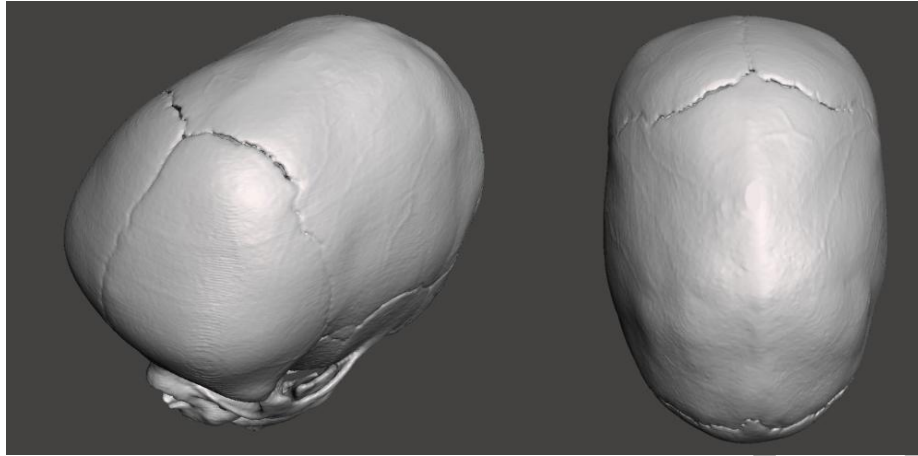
Head CT of a 4-month-old child with congenital craniosynostosis
